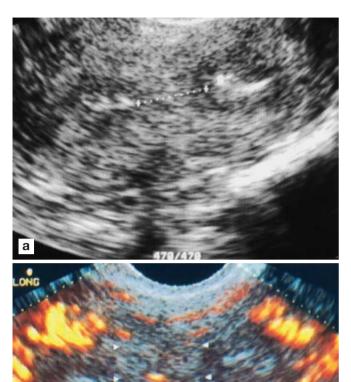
Transvaginal US of septate uterus. In a, the two cavities are well seen, and the distance between them is measured. b Power Doppler US demonstrates that the septum between the two cavities (*arrowheads*) is relatively poorly vascularized. This explains, at least in part, the high complication rates of pregnancies in septate uteri
